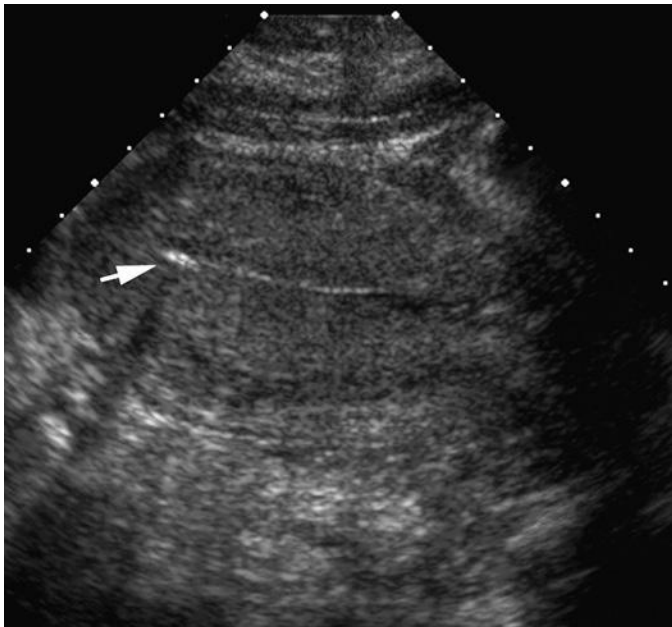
Transabdominal sagittal sonogram in a patient 1 week after cesarean delivery. Linear echogenic focus with dirty shadowing (arrow) consistent with air is seen within the endometrial cavity in the fundus. The endometrium was thin and normal. Air in the endometrial cavity can be a normal finding up to 2 weeks following cesarean delivery and can also be seen normally after vaginal delivery.
